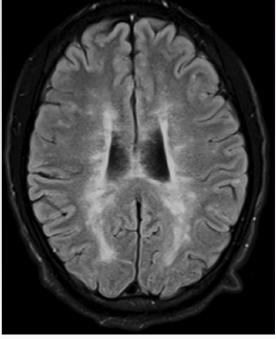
A sagittal and axial (horizontal) magnetic resonance image (MRI) of a patient with multiple sclerosis. Note the hyperintensity near the ventricles and the small plaques located in white matter regions.
